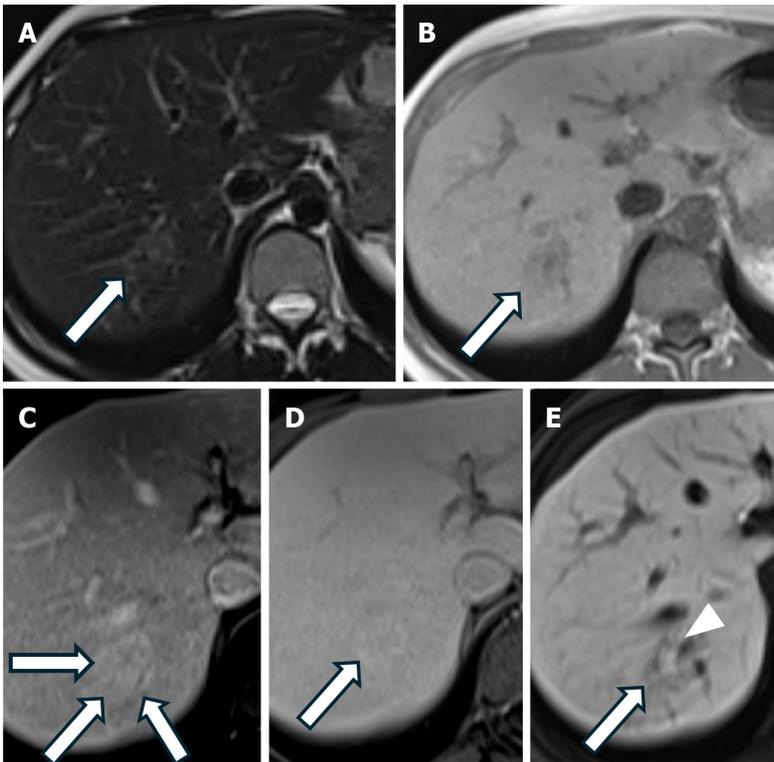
Focal nodular hyperplasia. A: Axial T2-weighted magnetic resonance imaging (MRI) shows a slightly hyperintense lesion (arrow); B: Axial T1-weighted MRI reveals a slightly hypointense lesion (arrow); C: Arterial phase T1-weighted MRI with a hepatobiliary-specific contrast agent shows homogenous enhancement of the lesion (arrows); D: Portal venous phase T1-weighted MRI indicates the lesion is isointense (arrow); E: Hepatobiliary phase T1-weighted MRI shows persistent peripheral enhancement of the lesion (arrow) with a hypointense central scar (arrowhead).
